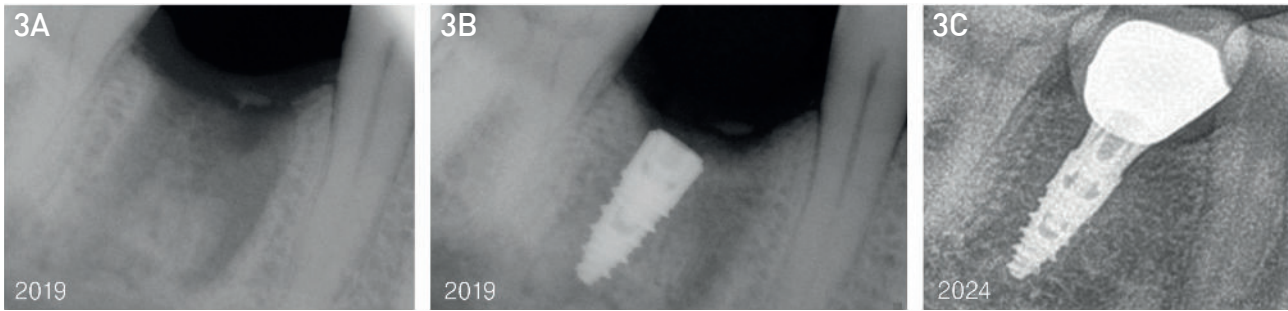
Healing extraction socket. Fig 3B: Torque-based implant (Intra-Lock LLC, USA) was placed with a torque range of 25 Ncm due to the low density of bone at the time of implant placement (2019), and functional loading was done after 4 months. Fig 3C: Bone gain is evident in follow-up x-ray of 2024.
